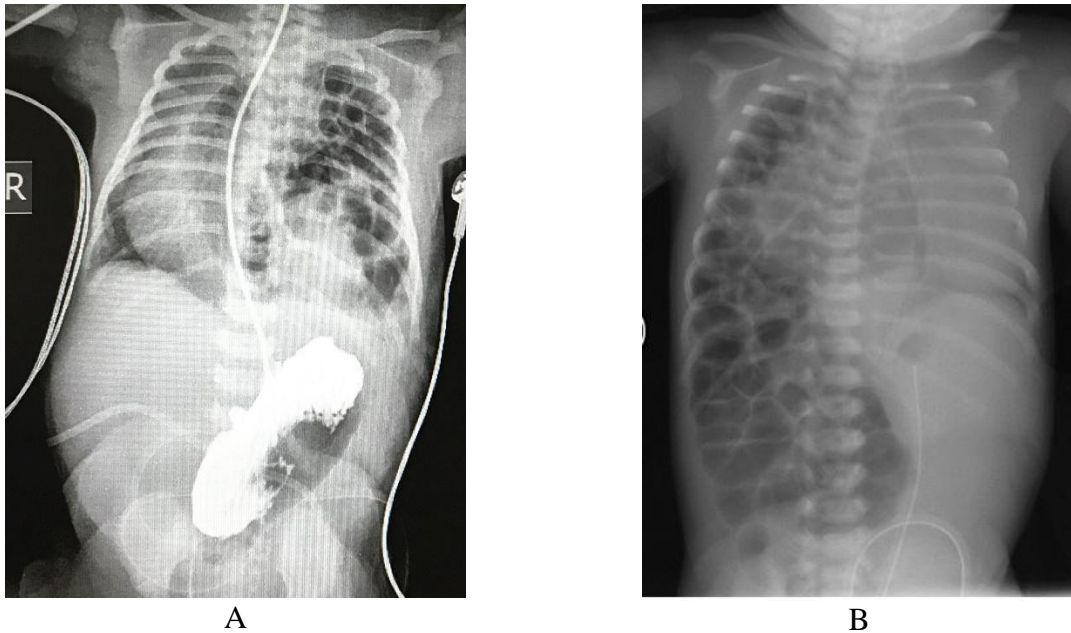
A - Plain chest radiograph in a newborn showing left-sided CDH. The air-filled loops of intestine are in the left hemithorax, mediastinum is shifted to the right. B - X-ray of the chest and upper abdomen showing right-sided diaphragmatic hernia
